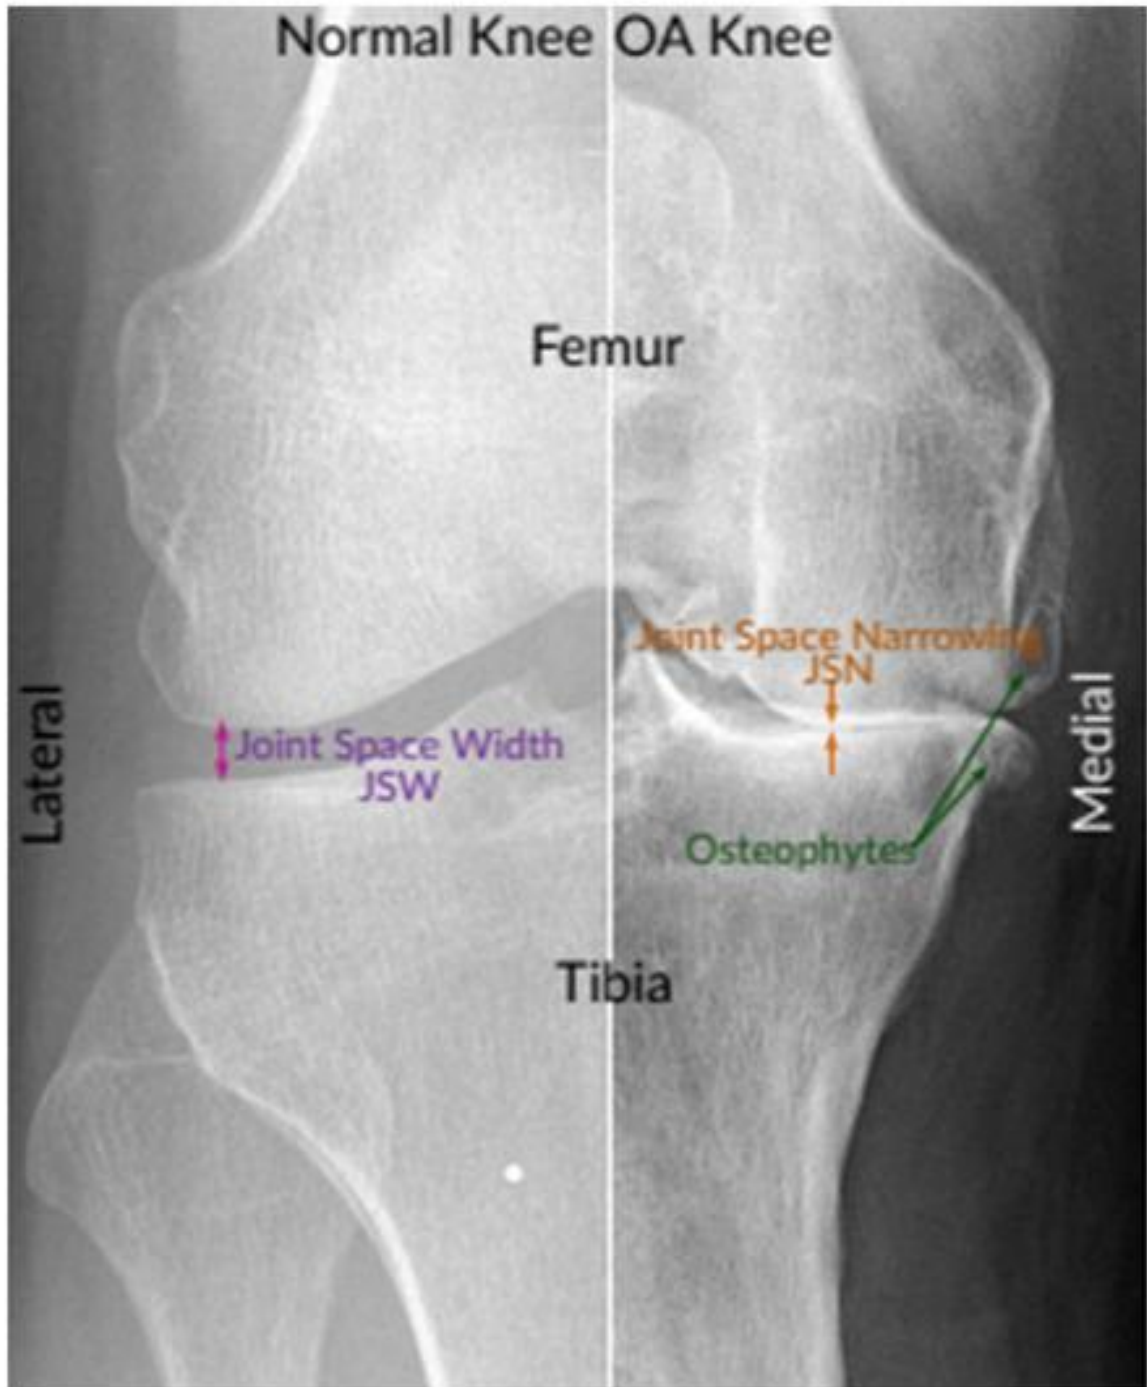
X-ray picture of normal and OA knee.²⁷
